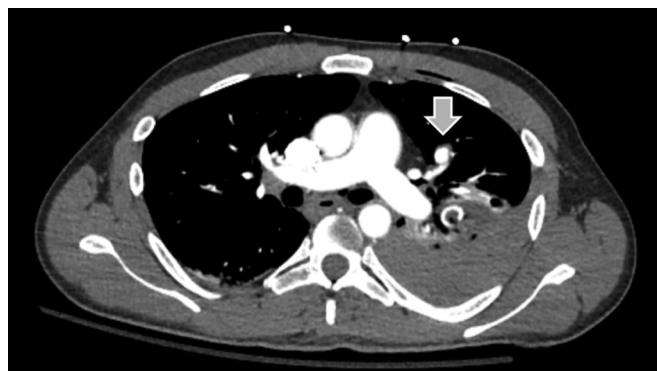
Axial image from CT angiogram showing left superior pulmonary vein pseudoaneurysm (arrow).
